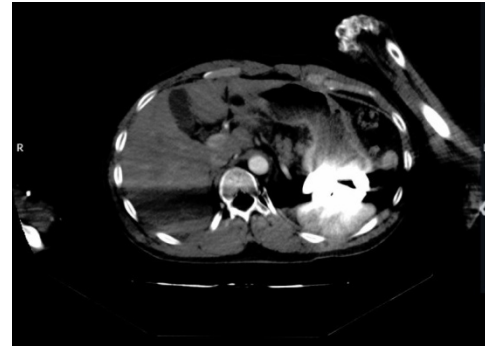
Foreign bodies observed as multiple metallic linear, identical appearances approximately in 1.5 cm thickness in stomach fundus during abdomen computed tomography
